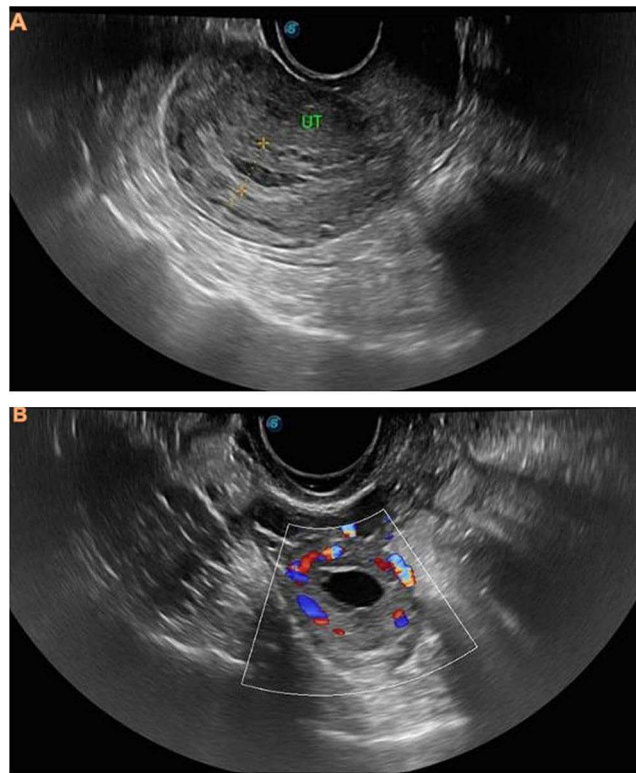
(A) Transvaginal ultrasound of the uterus in longitudinal (sagittal) view showing an empty uterine cavity with no visible intrauterine gestational sac. The endometrial thickness is measured at 11.27 mm. (B) Transvaginal ultrasound with color Doppler demonstrating a gestational sac located within or inseparable from the right ovarian tissue, with surrounding peripheral vascularity, supporting the sonographic diagnosis of presumed ovarian ectopic pregnancy. Notes: Letters denote the labeled structures or key findings, and yellow lines highlight the area of interest.
